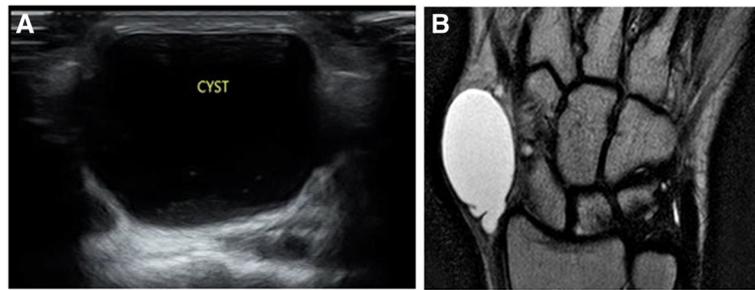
Cystic lesion; simple ganglion. a USG of radial side of the wrist demonstrates well-defined hypoechoic lesion with clear content and posterior acoustic enhancement. b MRI (coronal T2 WI) of the wrist demonstrates well-defined hyperintense lesion with clear content
